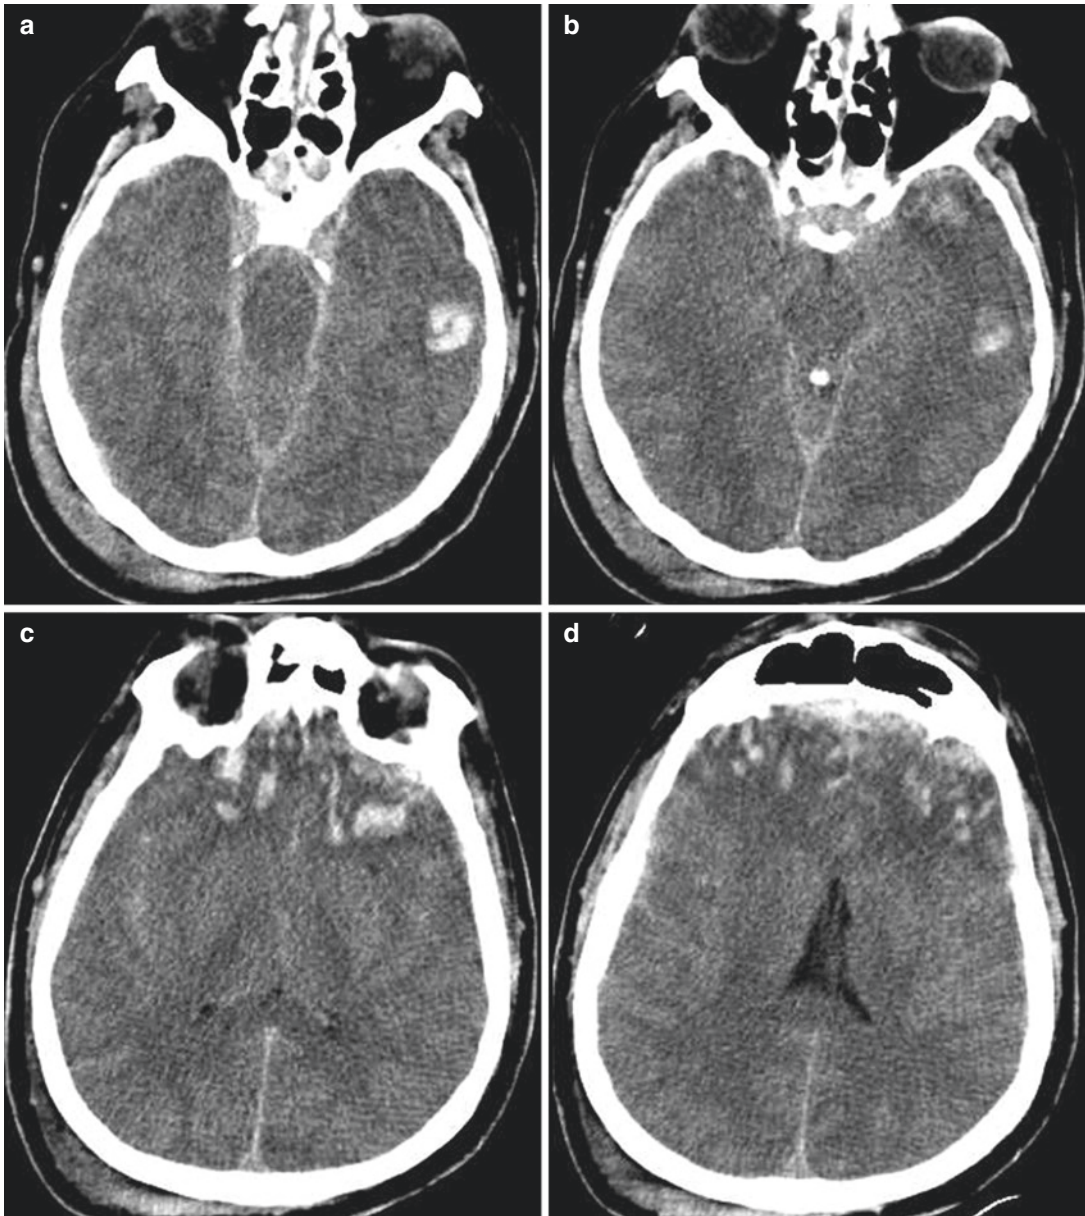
(a–d) CT scan. Hemorrhagic contusion: rounded-shaped and oval hyperdense foci at gyral surfaces of the frontal and temporal lobes, surrounded by edema
